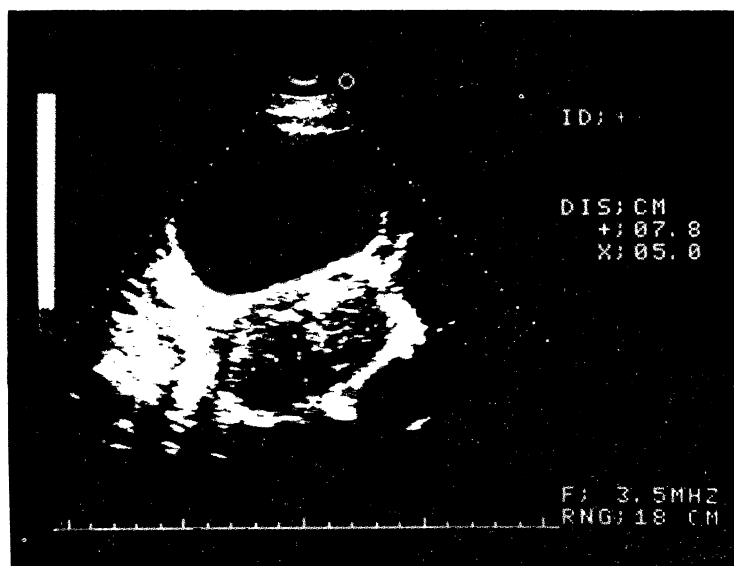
Sagittal sonogram: a large mixed-density mass suggestive for ovarian m.m.
